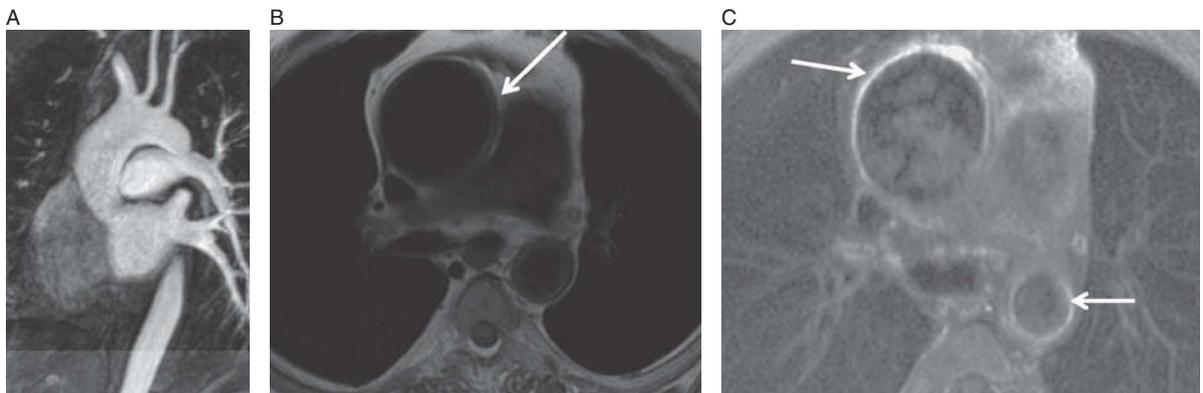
Takayasu's arteritis. Sagittal-oblique reformatted image from MRA (A) demonstrates what appears to be a normal aorta, but, remember, this is just the lumen-ogram. Dark-blood image (B) demonstrates aortic wall thickening with enhancement on T1-weighted post-contrast image (C). These cross-sectional images are critical for imaging vasculitis.
